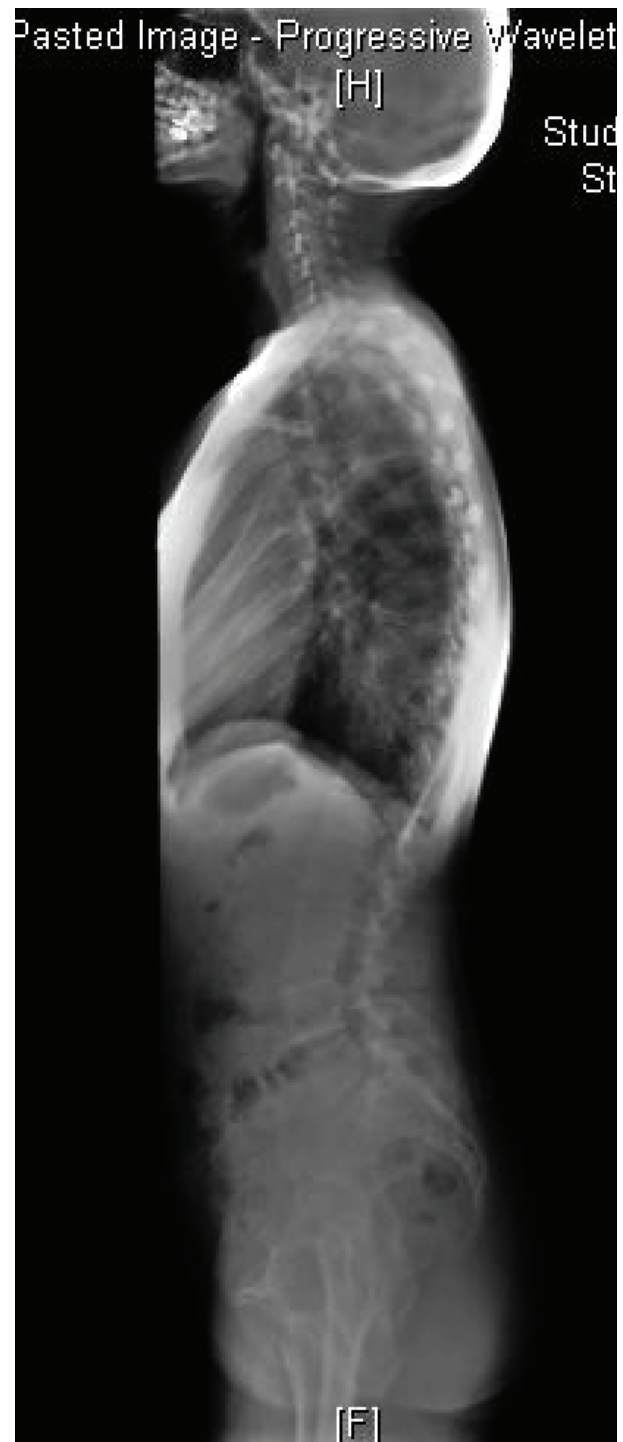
Whole spine lateral X-ray
